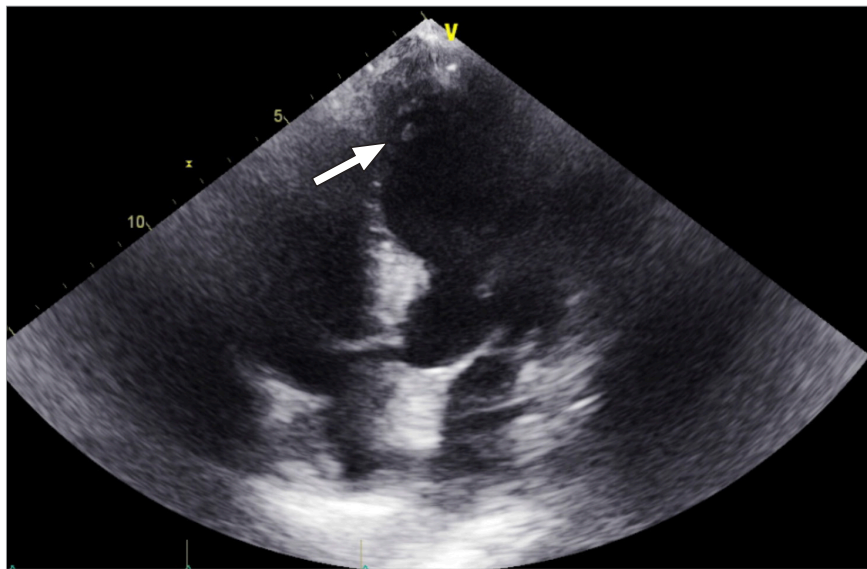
Transthoracic echocardiogram on admission shows an apical 4-chamber view with normal left ventricular size, wall thickness, and diastolic function; no apical ballooning (arrow); and an estimated left ventricular ejection fraction of 50% to 55%.
